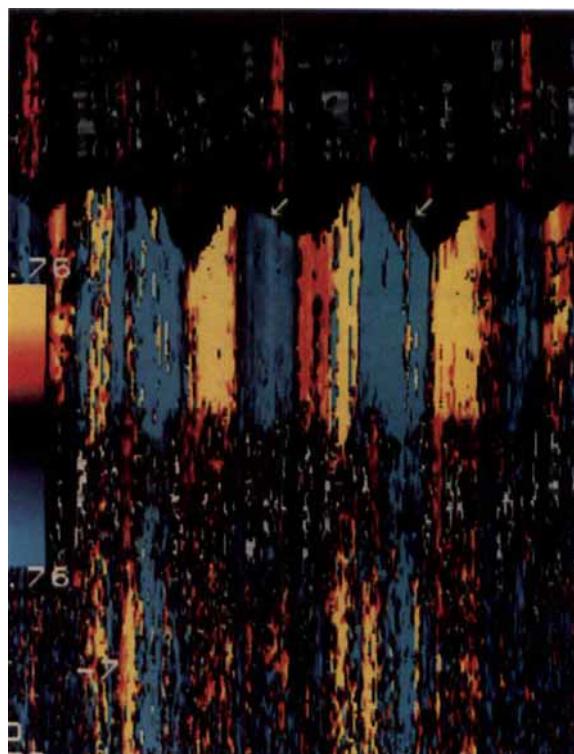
M-mode tissue Doppler imaging (TDI) demonstrates the motion of intra-aortic balloon pump (IABP) inflation and deflation (velocity range, 5.76 cm/sec).
